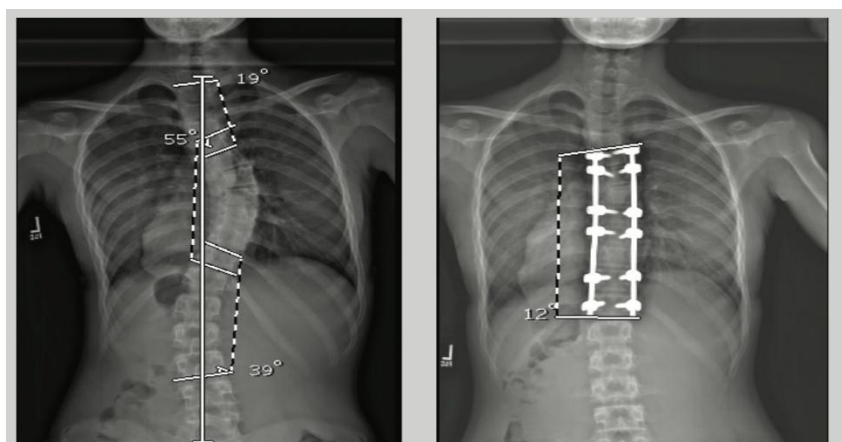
X-ray finding of surgical correction of thoracic scoliosis
